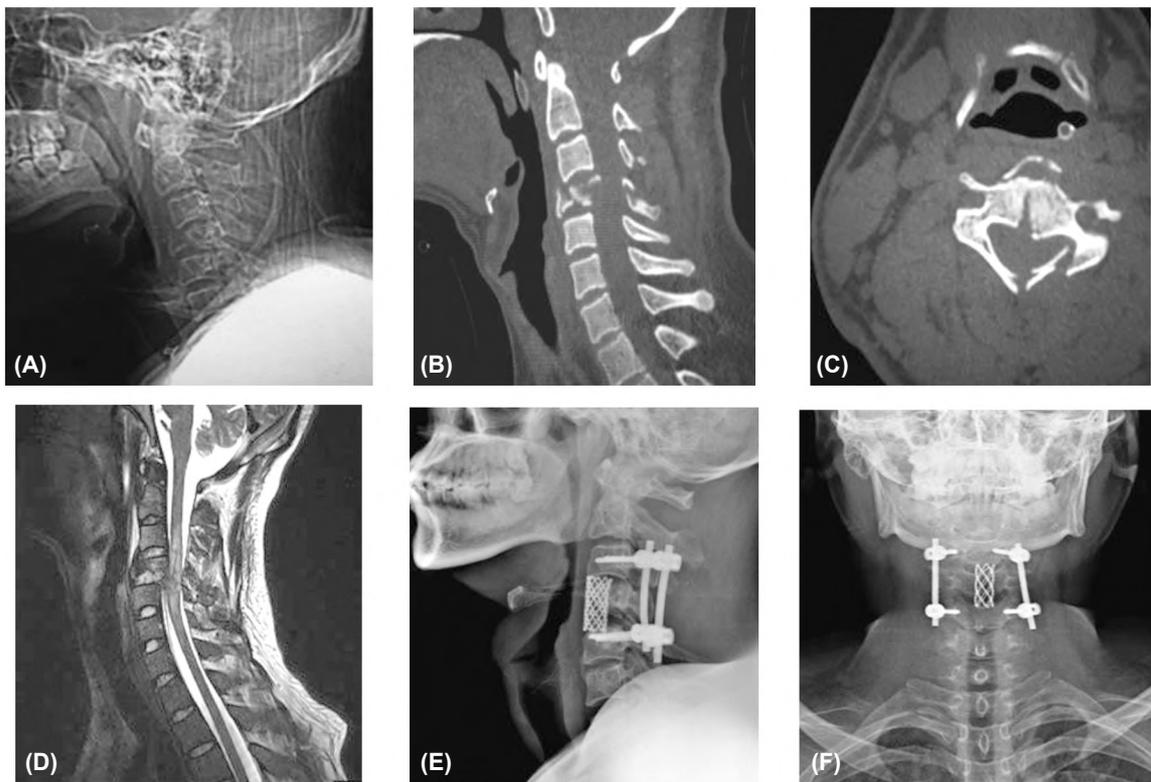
Preoperative (A) Plain X-ray film, (B) Axial CT, (C) Sagittal CT, and (D) Sagittal T2-weighted image showed C4 vertebra burst fracture with facets locked, the disc had been ruptured and the spinal cord was injured. Postoperative (E,F) Plain X-ray films show that the posterior pedicle screw fixation and ACCF of C4 were completed simultaneously.
